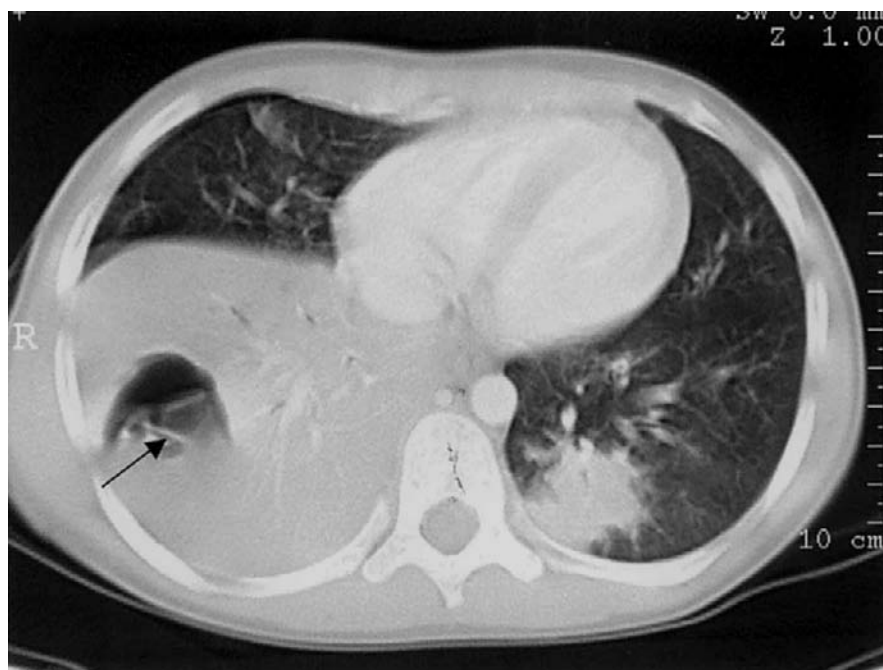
Contrast-enhanced chest CT scan confirming detached and collapsed cyst membranes (*arrow*) within a cavity characteristic of a ruptured hydatid cyst. Findings not previously seen on the radiographs include a second focal consolidation in the left lower lobe and a small right pneumothorax following pleurocentesis.
